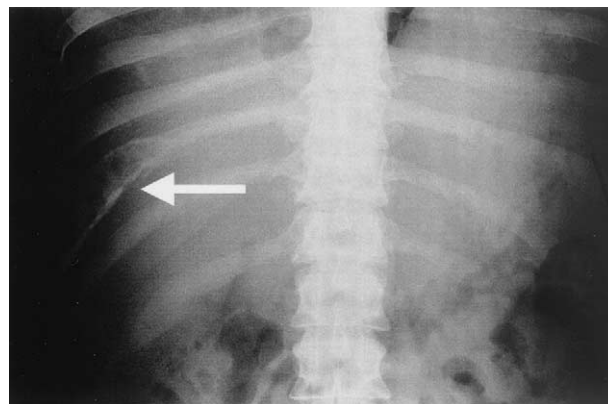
Chest roentgenogram showing a solitary expanding lesion in the right 10th rib (arrow).
